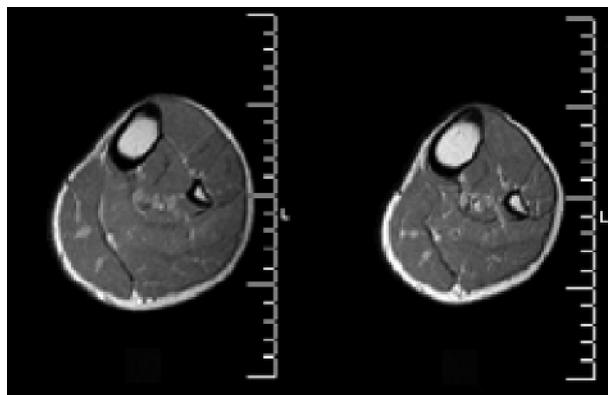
MRI images of the calf muscles taken before (left) and after 90 days of bed rest (right). Atrophy of the extensor muscles is most evident when comparing the two images.
